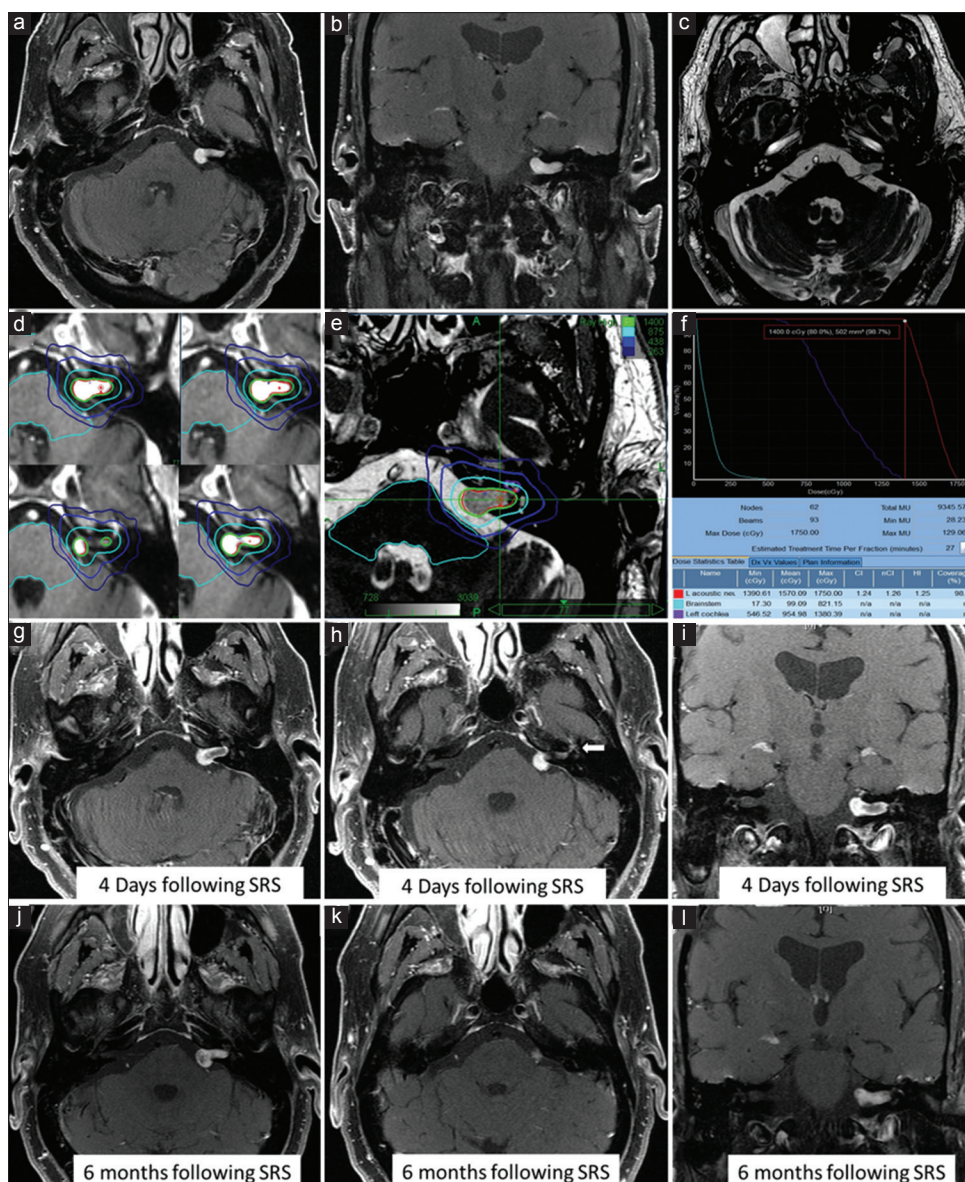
(a-c) Postcontrast and Fast Imaging Employing Steady-state Acquisition magnetic resonance imaging showing vestibular schwannoma in the left intrasellar arachnoid cyst (d-f) Treatment plan: Axial postcontrast and fast imaging employing steady-state acquisition magnetic resonance imaging showing targeted lesion in red, covered by the 14 Gy green prescription isodose line of 80%. Facial nerve received 4.4 Gy (light blue line). The red point represents maximum dose of 17.5 Gy (g-i) 4-day follow-up post-contrast magnetic resonance imaging's at the time of the acute facial weakness. The facial nerve tympanic segment and geniculate ganglion showed increased enhancement (arrow) (j-l) Postcontrast magnetic resonance imaging 6 months following stereotactic radiosurgery with overall stable size of the tumor
